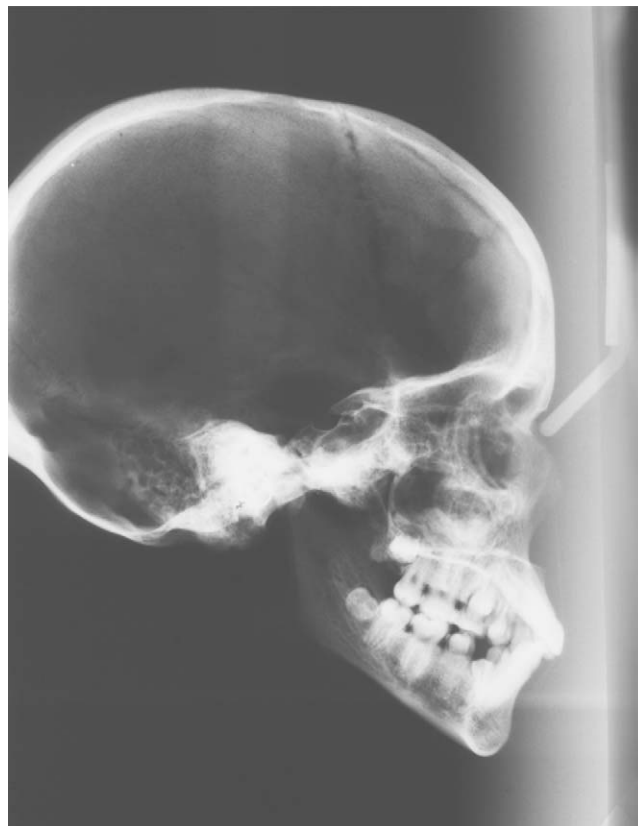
Lateral cephalometric radiograph of "Myrtis."
